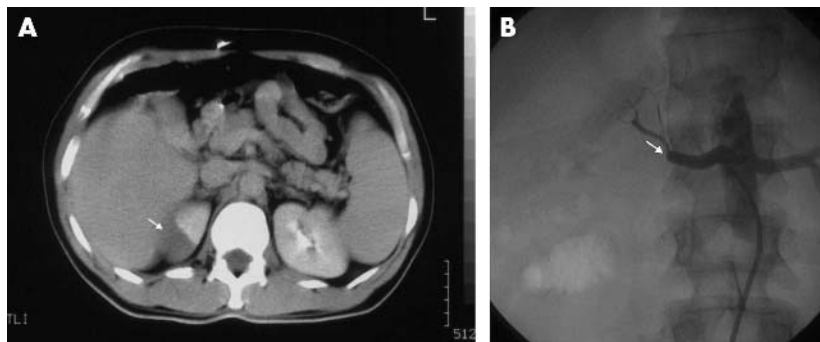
(A) Computed tomography with contrast agent revealed right renal infarction with only upper pole perfusion (arrow). (B) Selective right renal angiography. Note the total occlusion of the renal artery (arrow).
